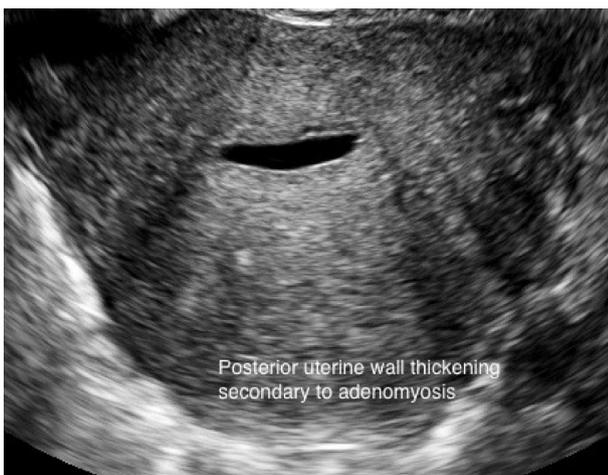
Sonogram (Kindly provided by Dr Yasmin Tan WHRIA with permission.)
